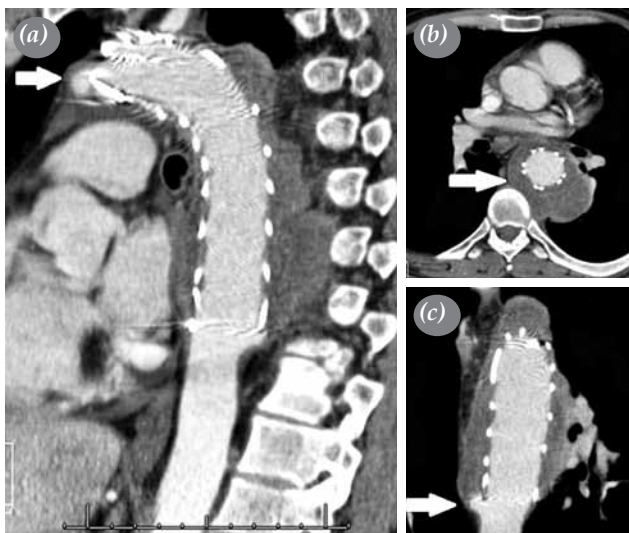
Computed tomographic angiography showing (a) the saccular pseudoaneurysm proximal to the stent graft, (b) the pseudoaneurysm sac formation surrounding the stent graft in the descending thoracic aorta, and (c) the saccular pseudoaneurysm formation at the distal landing zone of the stent graft, which was complicated by an aortobronchial fistula.
